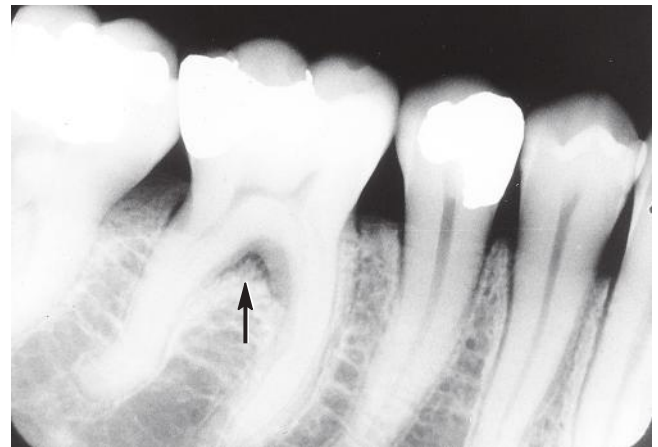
Early occlusal trauma noted radiographically with a widening of the radiolucent periodontal ligament space (*arrow*) between the radiopaque lamina dura of the alveolar bone proper and the similarly radiopaque cementum; thickening of the lamina dura in response is also possible. (Courtesy of Margaret J. Fehrenbach, RDH, MS.)
